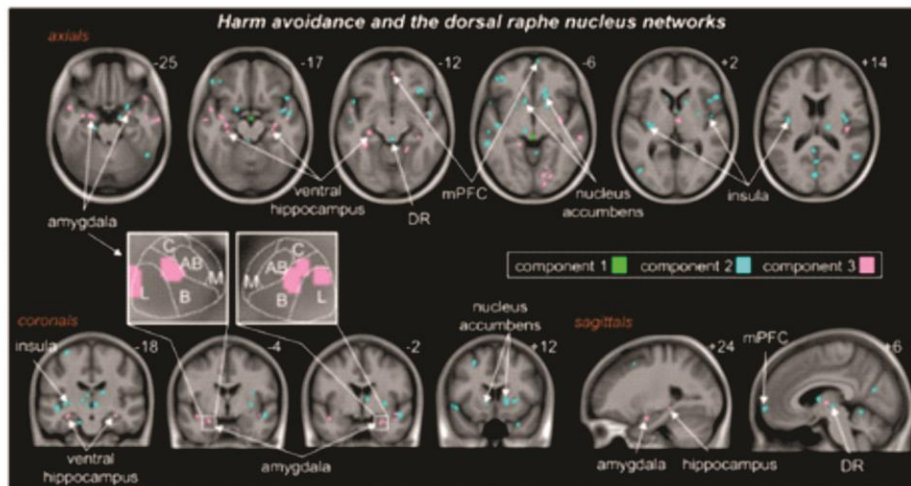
Resting-signal intensity fluctuations of the previously defined networks significantly correlated to harm avoidance (HA) were overlaid on a mean T1-weighted anatomical image set. Note that resting-signal connectivity was correlated with HA in a number of regions in the region of the dorsal raphe nucleus (DR), the left and right amygdala in the region of the basal and basolateral nuclei, left and right ventral hippocampus, left and right
